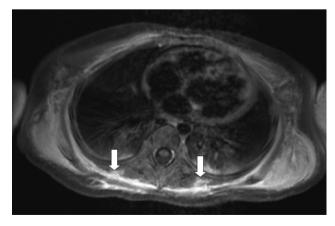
T1-weighted magnetic resonance image at presentation revealed multiple inhomogeneous mass and high signals over the paraspinal area (white arrows).
